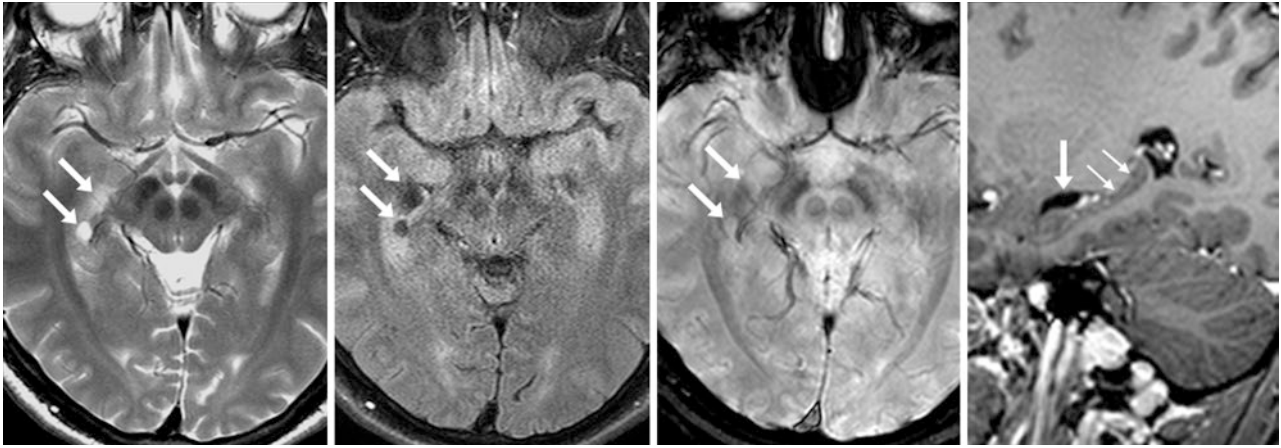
A 36 year old was given a 3 T MRI, including axial T2WI (*left*), FLAIR (*left middle*), SWI (*right middle*), and postcontrast sagittal T1WI (*right*). The images showed asymmetry of the right choroidal fissure, probably from two cystic foci (*arrows*) without mass effect or
